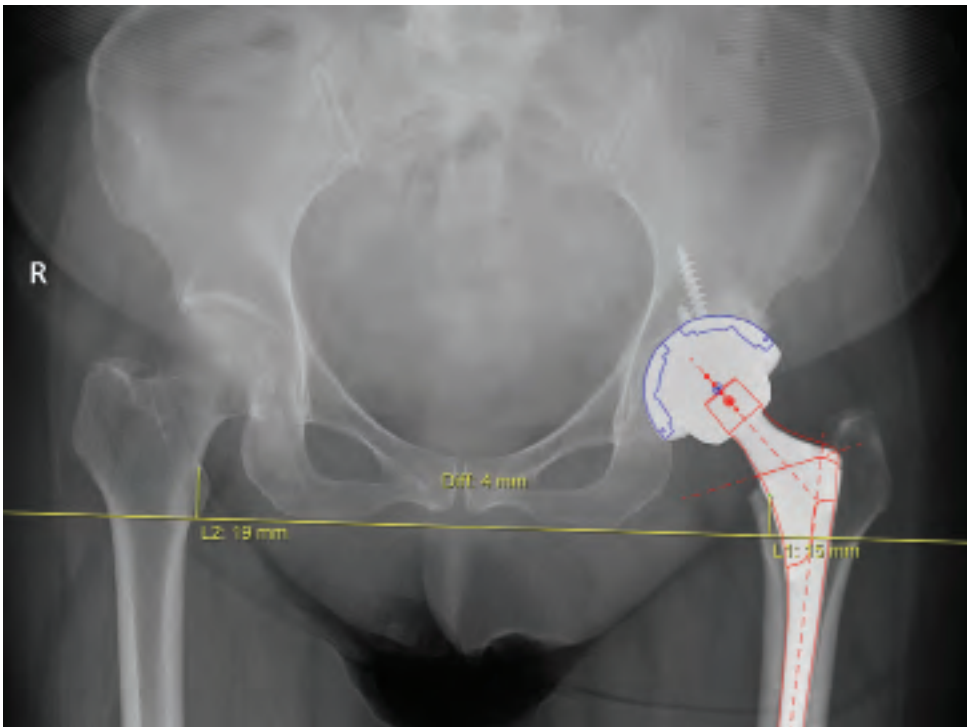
Postoperative x-ray with template demonstrating the actual implant and size selected. Leg length discrepancy improved to within 4 mm.
